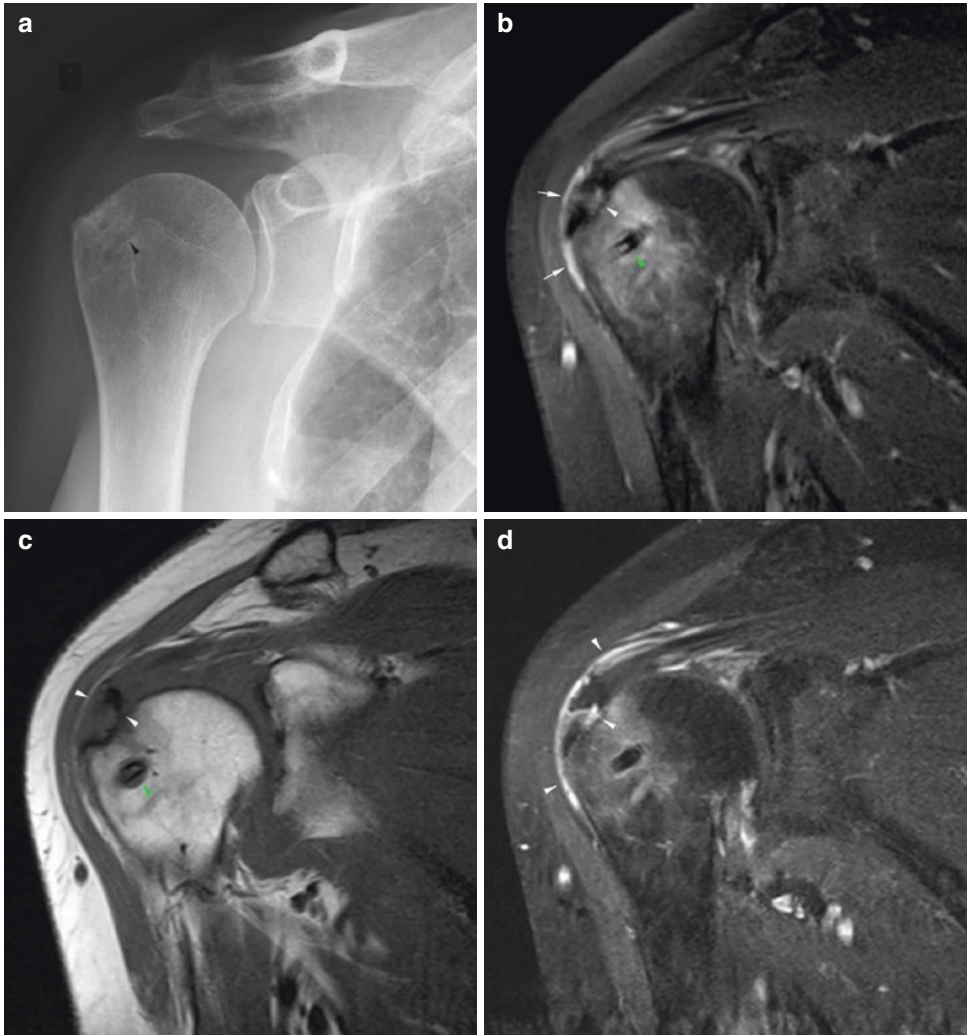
(a–h) Supraspinatus tendon repair follow-up. (a) Frontal radiograph of the shoulder post supraspinatus reinsertion. The bioabsorbable suture anchor track is barely appreciated (arrowhead). (b) T2-weighted FatSat coronal MR image. The suture anchor is visible with mild osteolysis and edema of the surrounding bone marrow, normal for several weeks to months after surgery. There is no dislocation of the anchor (green arrowhead). The supraspinatus tendon is thickened, and its signal is very heterogeneous, also normal in the postoperative period. There is a small focus of fluid signal intensity in the articular side of the tendon footprint (white arrowhead), non-specific (could be granulation tissue, a small residual communication or a small type 1 retear of the tendon). Bursitis-like signal intensity is seen in the subacromial bursal space, a normal finding for many months after surgery. (c) The corresponding T1-weighted coronal image. (d) T1-weighted FatSat Gad coronal image. This is a T1-weighted image with fat saturation and intravenous gadolinium. Inflammatory and granulation tissue takes up
